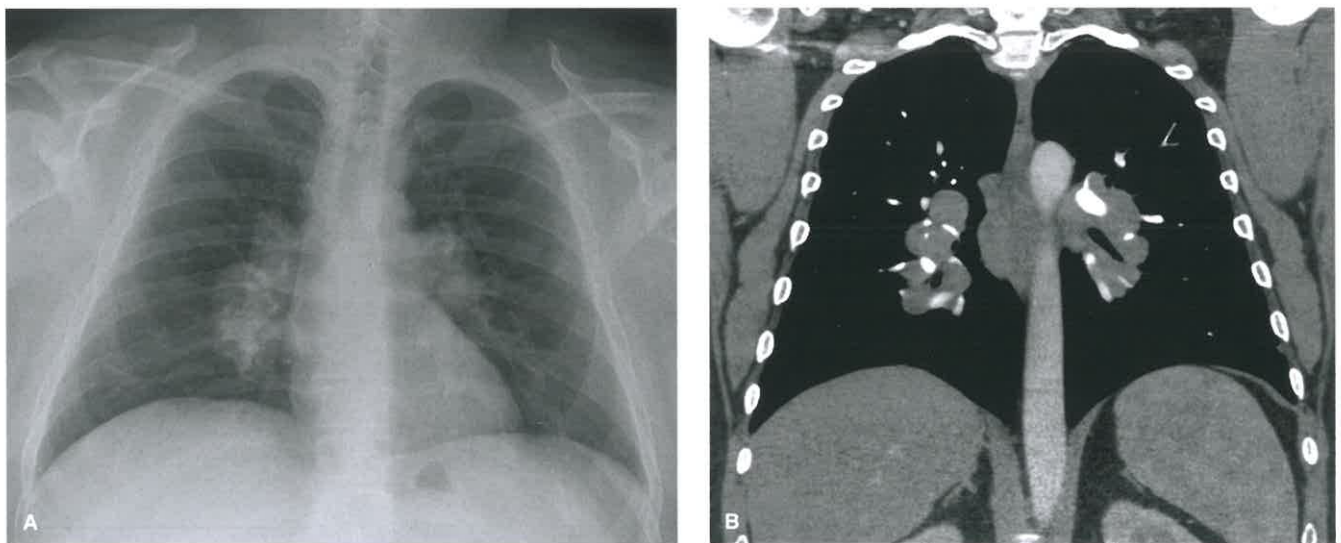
Bilateral Hilar Lymph Node Enlargement in Sarcoidosis. A: Posteroanterior radiograph in a 46-year-old man with sarcoidosis reveals bilateral hilar lymph node enlargement with subtle upper and mid-lung reticulonodular opacities. B: Contrast-enhanced coronal CT at the level of the carina shows bilateral hilar lymph node enlargement.
